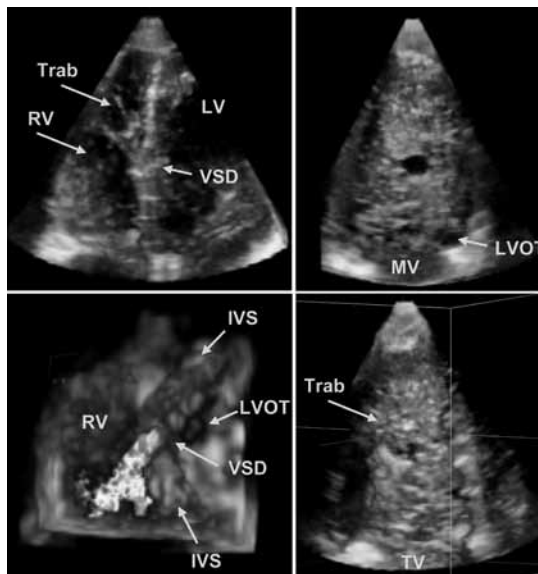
Example of transthoracic RT3DE representation of a small muscular ventricular septal defect (VSD) which is covered by marked trabeculation (Trab) on the right ventricular side of the interventricular septum (IVS; top left). The 3D en face view from the left ventricle (LV) to the IVS provides clear visualization of size, shape, and location of the VSD (top right), whereas the en face view from the right ventricle (RV) to the VSD is obscured by the trabeculation (bottom right). The 3D color Doppler short-axis view from the apex to the IVS shows the eccentric direction of shunt flow through the VSD (bottom left). LVOT left ventricular outflow tract, MV mitral valve, TV tricuspid valve.
